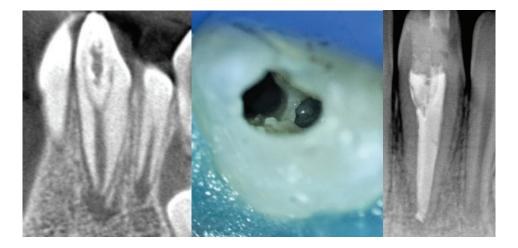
Treatment of dens invaginatus by technique of anatomical redesign: forming connection between lingual pulp horn and dens invaginatus, root canal treatment and obturation with guttapercha (clinical photo and X-rays images provided from clinical practice of Dr. Volodymyr Fedak)
